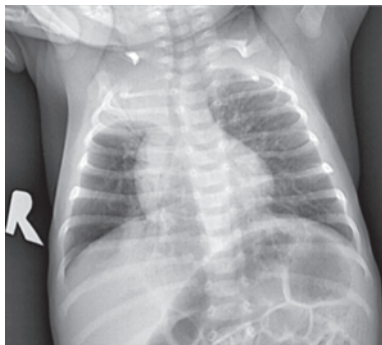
X-ray chest: Right upper lobe collapse - Minor fissure pulled up, right diaphragm elevated and trachea shifted to right
